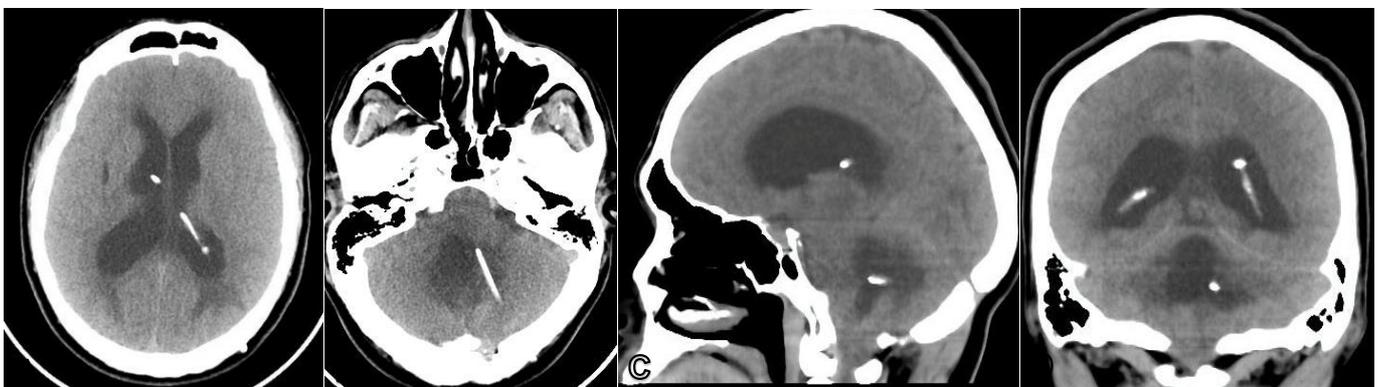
(A and B) Cerebral CT scan on admission, in axial section at the level of lateral ventricles and the fourth ventricle showing marked ventricular dilation with transependymal edema in addition to diffuse cerebral edema. (C and D) Cerebral CT scan in sagittal section and coronal section showing ventricular dilation and left parietooccipital and posterior fossa catheters.
